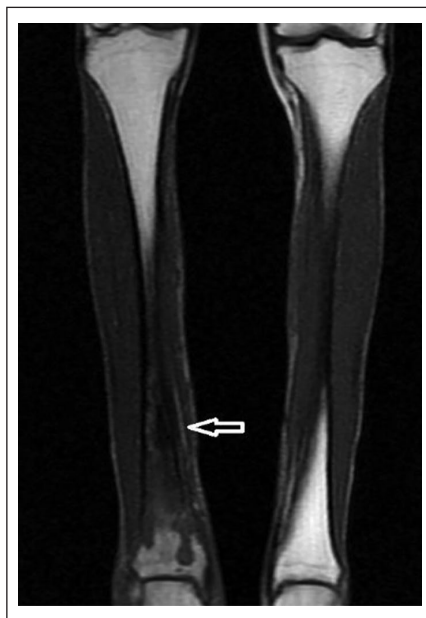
Hypointense and serpiginous appearance in the metaphyseal-diaphyseal intramedullary region which is typical for Brodie abscess. The thickness of the cortical bone and the accompanying periosteal reaction (arrow) is noteworthy on the coronal T1-weighted FSE image.
